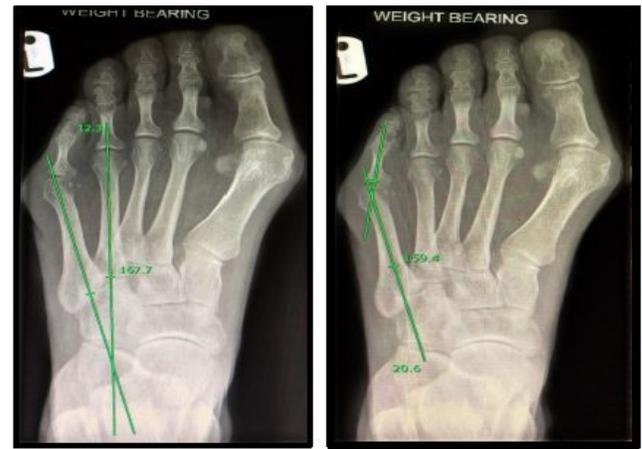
Image A, B: Pre-op weightbearing radiograph of Tailor's bunion
